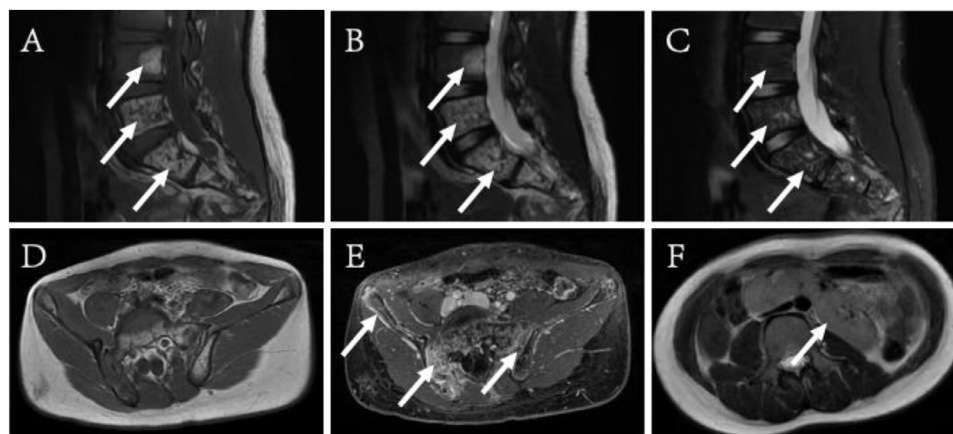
MRI of the spine and pelvis. (A) Hyperintensity on sagittal T1-weighted image (T1WI), (B) hyperintensity on sagittal T2-weighted image (T2WI) and (C) hypointensity on sagittal T2-weighted fat saturation (T2-FS) showed the lesions in L4, L5 and sacrum (white arrows); (D) Axial T1-weighted image (T1WI) and (E) the contrast-enhanced MRI demonstrated the osteolytic lesions and the soft tissue in the right ilium and sacrum enhanced obviously and the synovial membrane in sacroiliac joints was thickened and enhanced homogeneously (white arrows); (F) Horseshoe kidney (white arrow).
